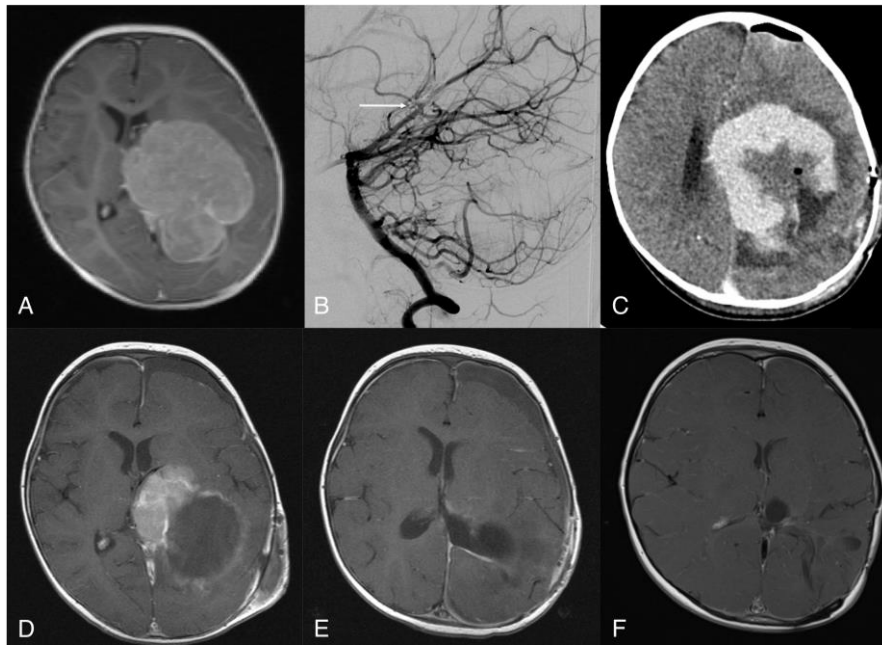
Eleven month-old girl with a large left hemispheric choroid plexus carcinoma. The patient underwent pre-operative embolization followed by staged resection, involving three craniotomies over four weeks. Despite tumor embolization, intra-operative blood loss remained a significant problem, and limited the first and second procedures. Following surgical recovery she underwent 6 courses of Cyclophosphamide, Etoposide and Vincristine chemotherapy over 6 months. A, pre-operative MR scan showing large enhancing left hemispheric lesion. B, pre-operative digital subtraction angiogram, lateral view of left vertebral artery contrast injection showing glue embolization of tumor-supplying left posterior choroidal artery (black arrow). C, contrast-enhanced axial CT scan after first craniotomy and resection. D, MR scan after second craniotomy showing significant reduction in tumor volume. E, MR scan after third craniotomy with gross total resection of tumor; this was followed by chemotherapy. F, 2-year follow up MR scan showing no tumor recurrence. All scans are axial T1-weighted post-Gadolinium MRI.
